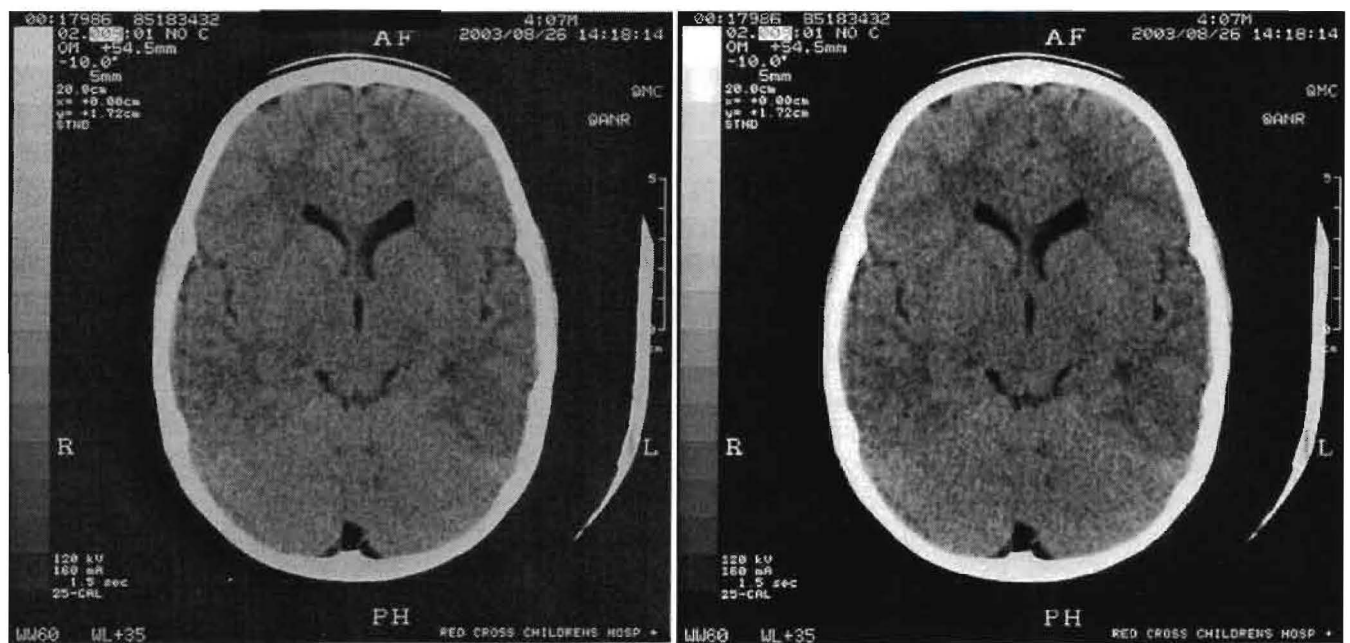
Showing 2 normal head CT images. The image on the right has undergone contrast stretching
